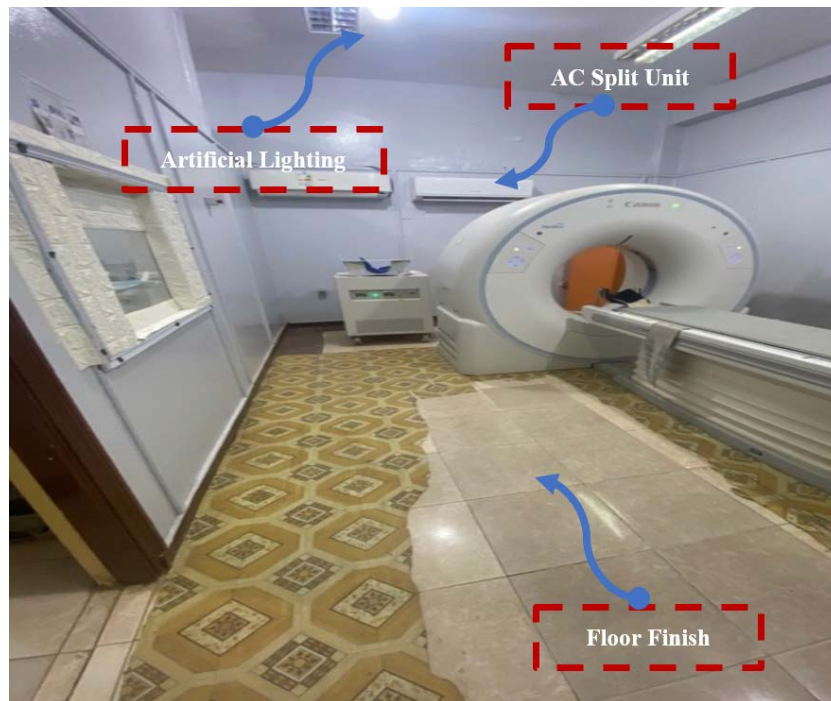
CT scan room with irrelevant ventilation system - researcher
